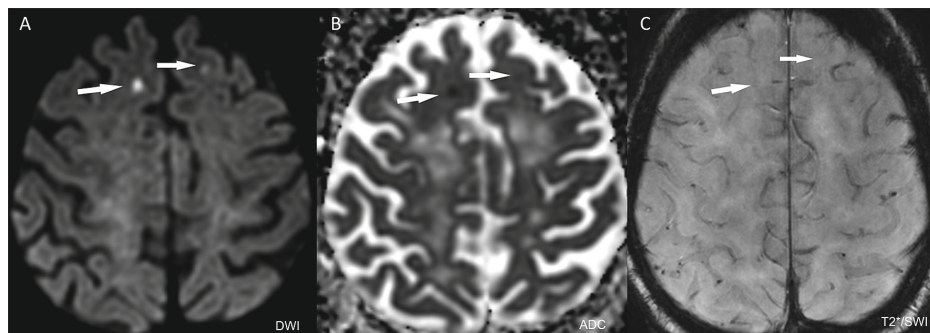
Example of two ACMI in a single patient. Two ACMI (arrows left and right frontal lobe) in one patient. (A) There is a hyperintens signal on DWI, (B) corresponding hypointens signal on ADC and (C) isointens (i.e. not distinctly visible) signal on T2*-weighted image (right).
